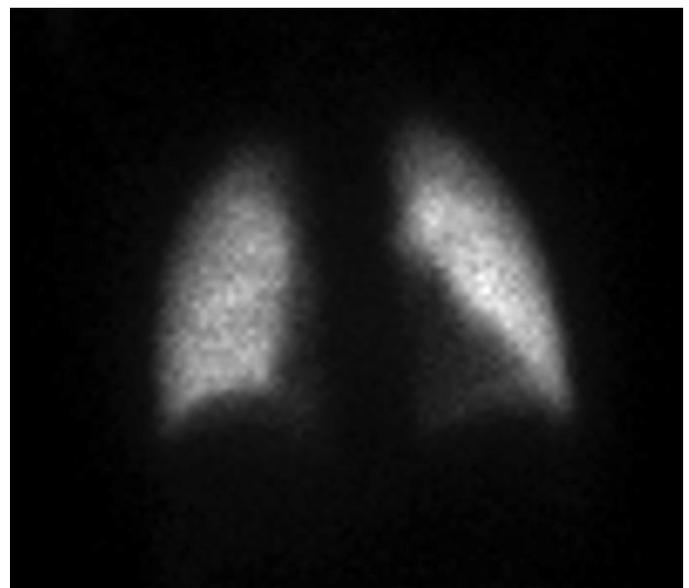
The scintigraphy shows a normal pulmonary perfusion
